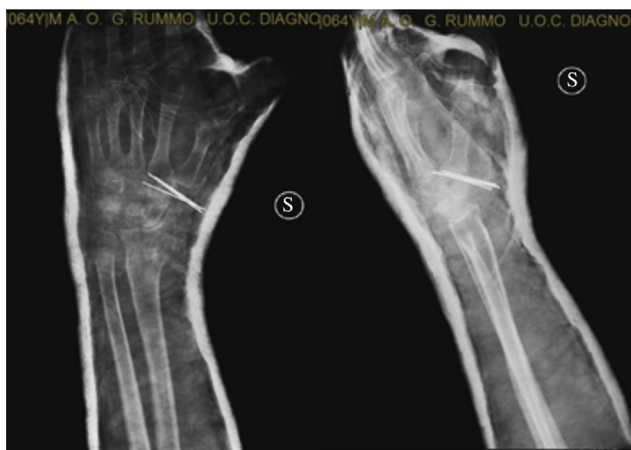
X-ray in the brace (AP and LL projections) after surgery showed the correct reduction of the trapezium fracture.
